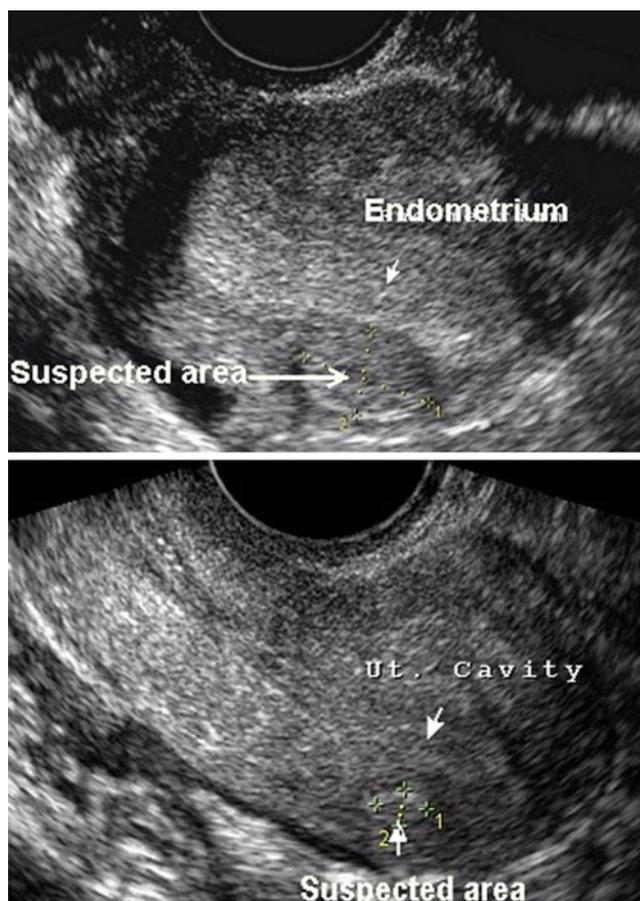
a Shows an oblique view of a uterus during the luteal phase with 14.8×8.6 mm circumscribed area of similar texture and echogenicity to the overlying and adjacent endometrium, reminiscent of adenomyosis. b Shows early follicular phase anterior/posterior ultrasound picture of the same uterus depicted in a. The size of the suspected adenomyotic area shown in a is reduced to 5.3×3.8 mm
